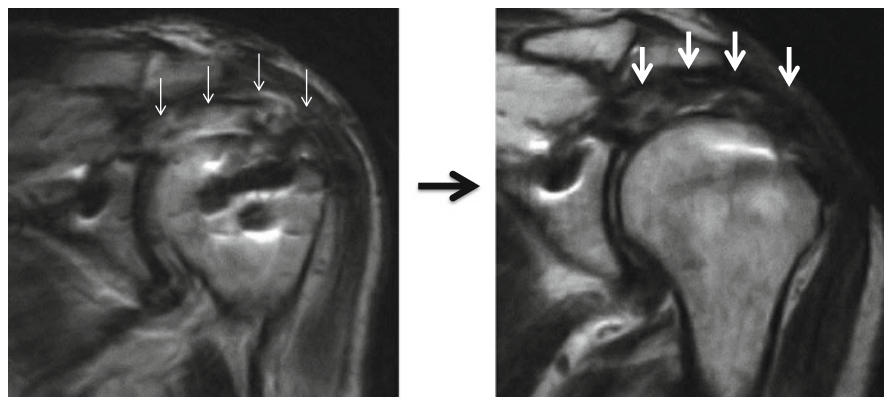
MRI findings after superior capsule reconstruction. *Left*: When some of the fatty tissue was not removed during surgery, T₂-weighted MRI 3 months after surgery showed both low- and high-intensity areas in the graft (*white thin arrows*). *Right*: 1 year after surgery, the graft (*white thick arrows*) was thicker and the low-intensity area had increased on T₂-weighted MRI
